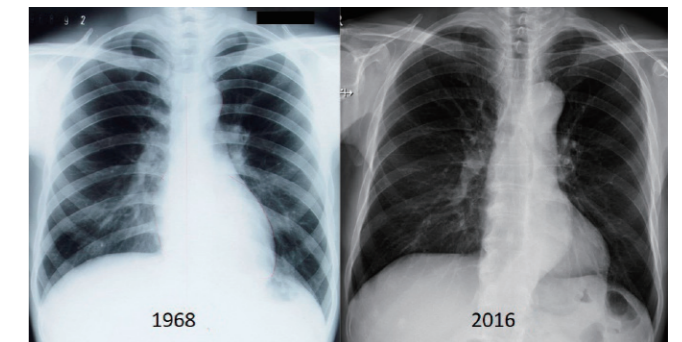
Chest x-ray photograph
